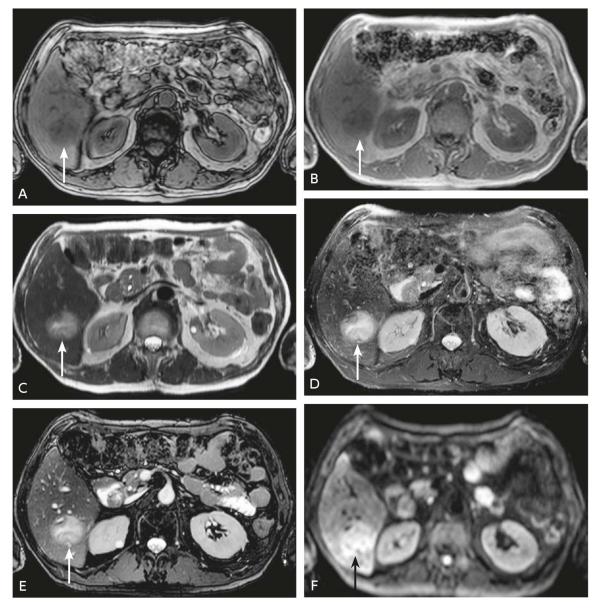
Non-contrast MRI (moderately differentiated hepatocellular carcinoma)
